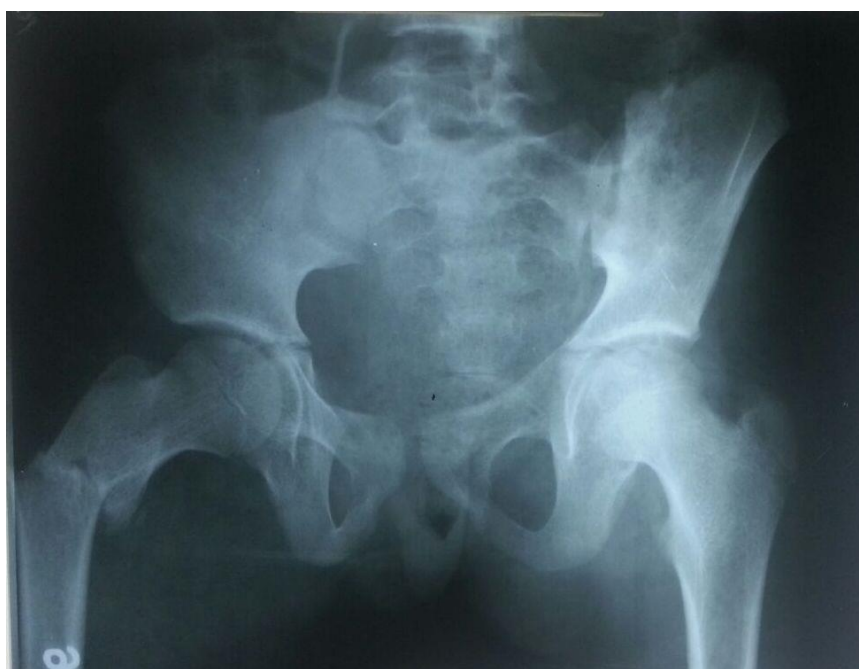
Pre-operative x-ray at 2 weeks of pelvis with both hip showing displaced sub trochanteric femur fracture
